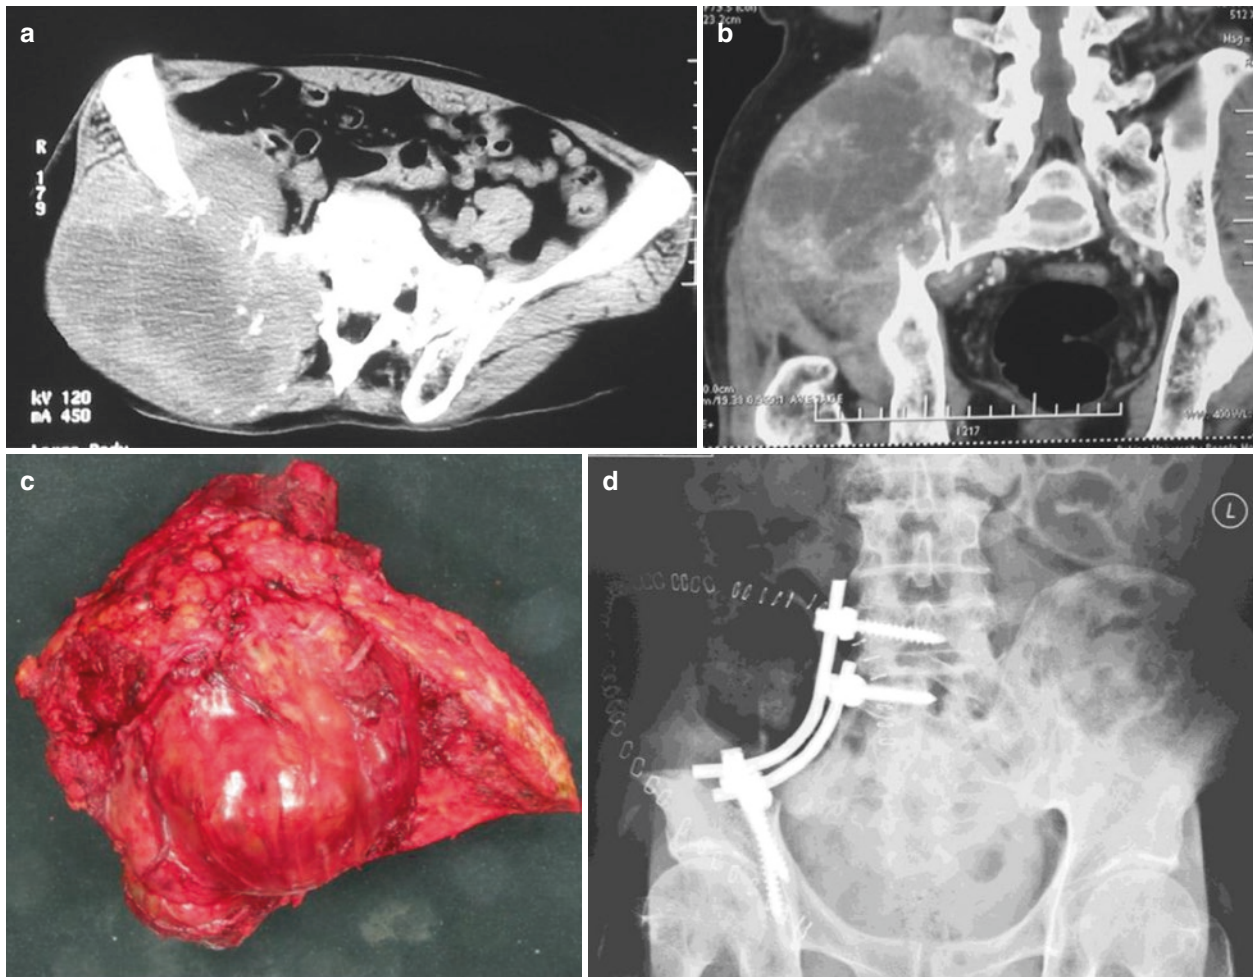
The patient was a 72-year-old female with diagnosis of giant cell tumor of right ilium. Preoperative axial and coronal CT showed the lytic destruction of right pelvis with sacroiliac joint involved (a, b). (c)
